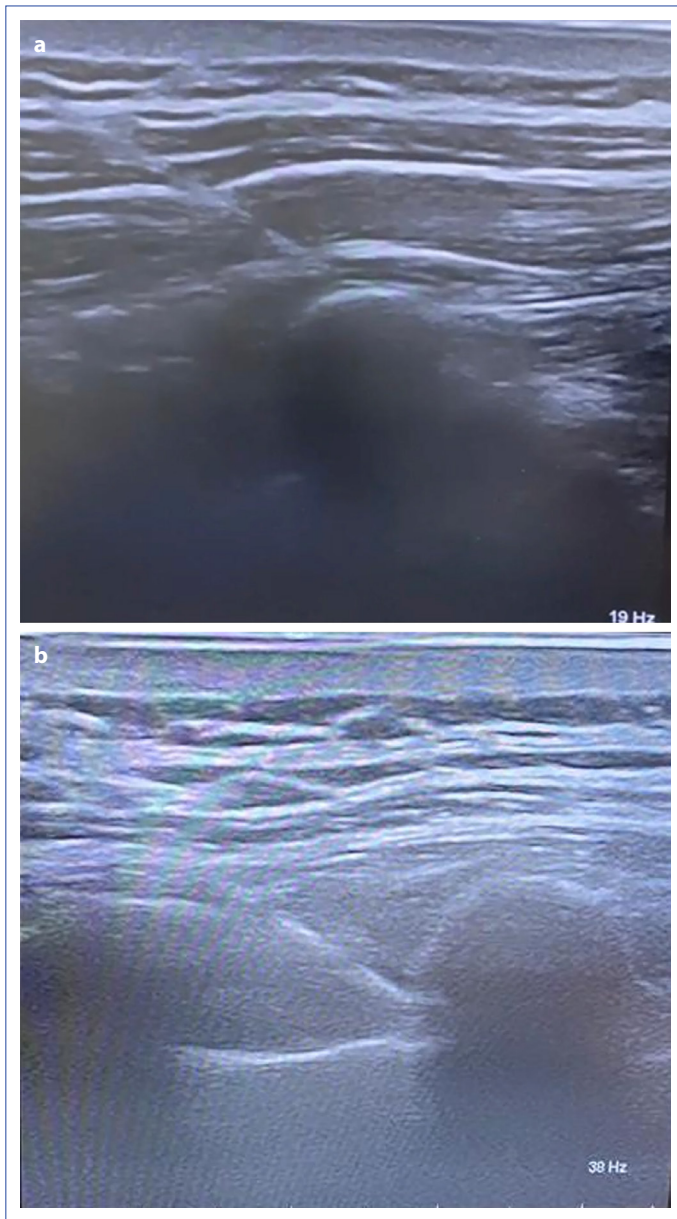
(a) Sonographic image of the erector spinae plane block. (b) Sonographic image of the thoracic paravertebral block.
